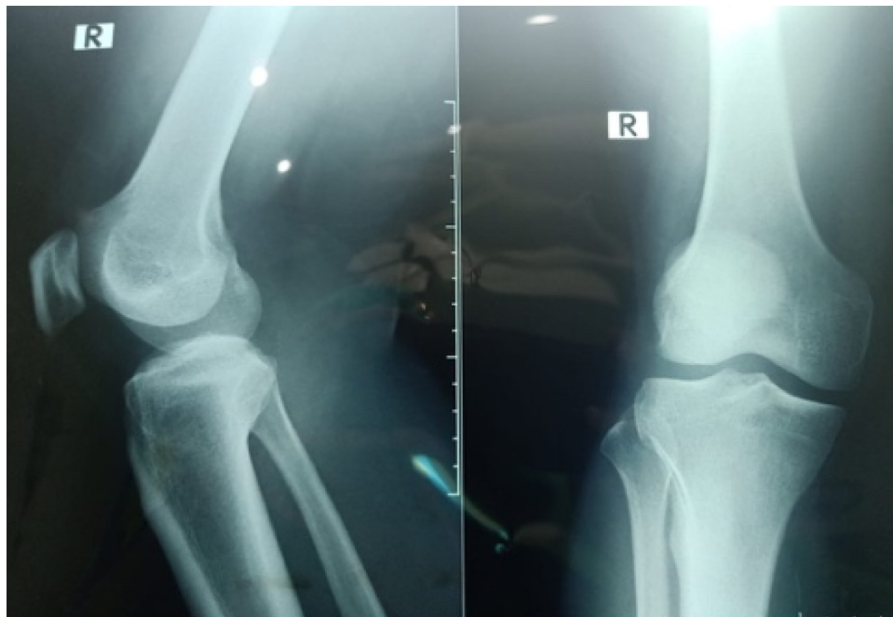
Knee Radiographic.
